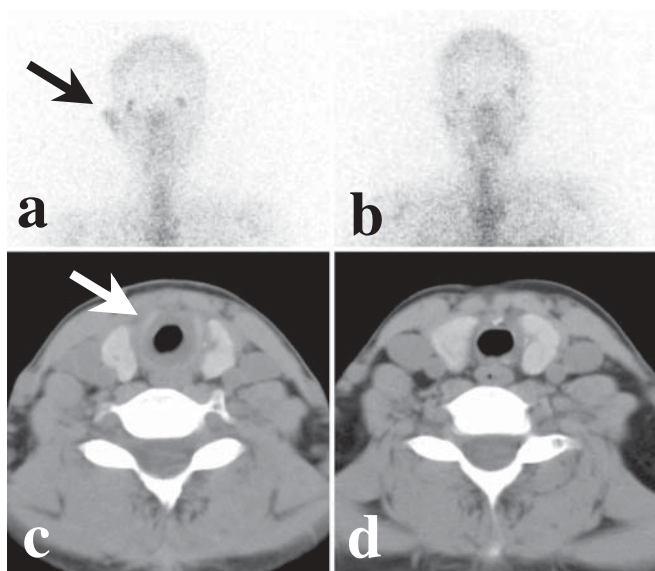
Gallium scan showing increased uptake in the right ear (a; arrow) and CT scan showing swelling of the tracheal mucosa (c) with improvement after treatment (b and d)
